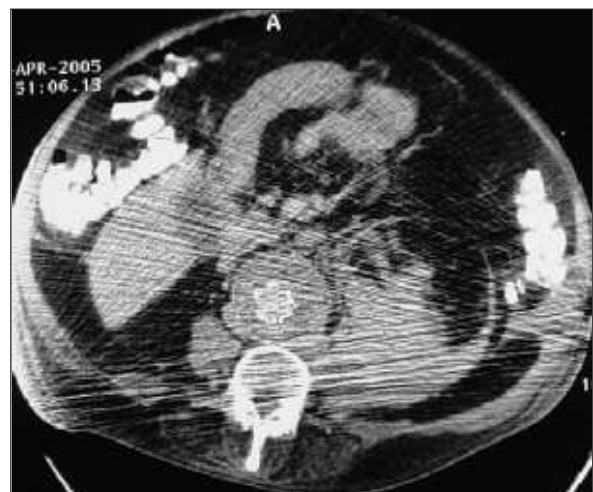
Abdominal CT evaluation of the same patient on the second postoperative day. (The image is artifacted). Note that there is no change in the extent of the hematoma and well placed stent-graft inside the aneurysm sac without any prominent endoleak.
